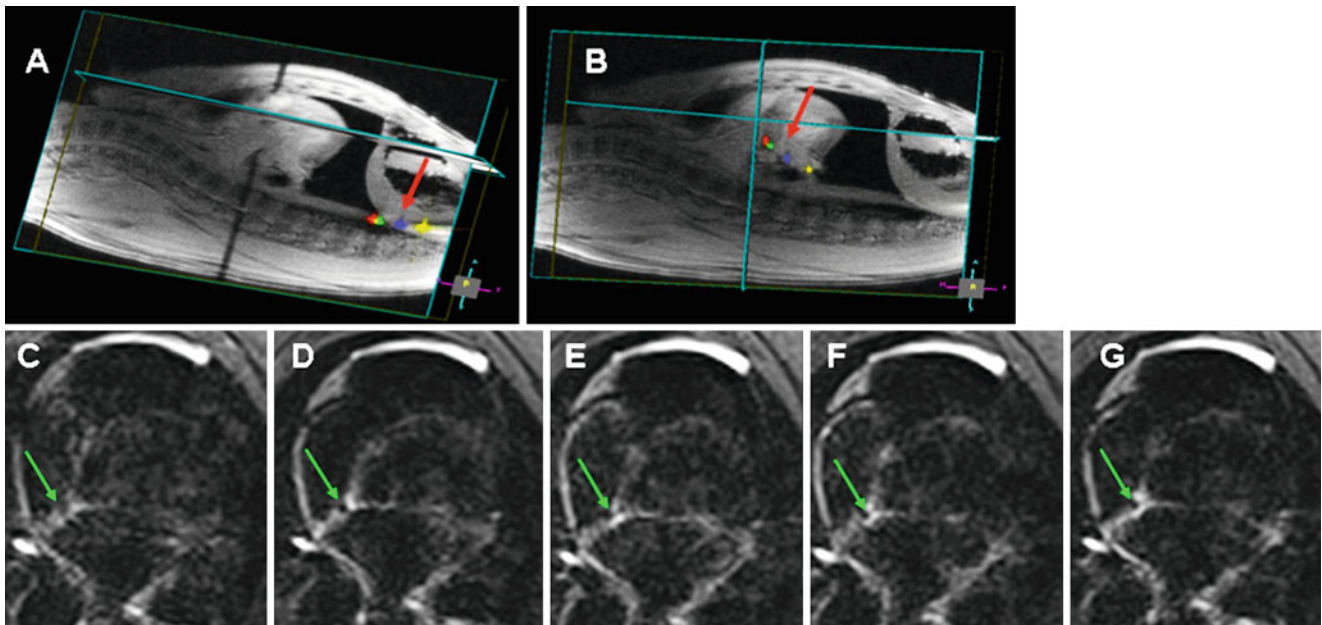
Real-time MRI ablation and lesion visualization at 3-T. (a and b) MRI-compatible RF catheter guided under RT-MRI from the IVC into RA, the signal from the tracking elements is displayed and color coded (red: distal and yellow: proximal) to allow the operator
